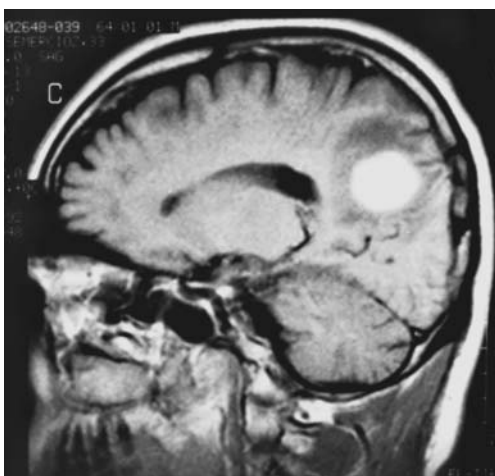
Sagittal T₁-weighted magnetic resonance image with contrast medium performed 24 weeks after the trauma showing a well-circumscribed homogeneously enhanced lesion in the left posterior parietal region.
